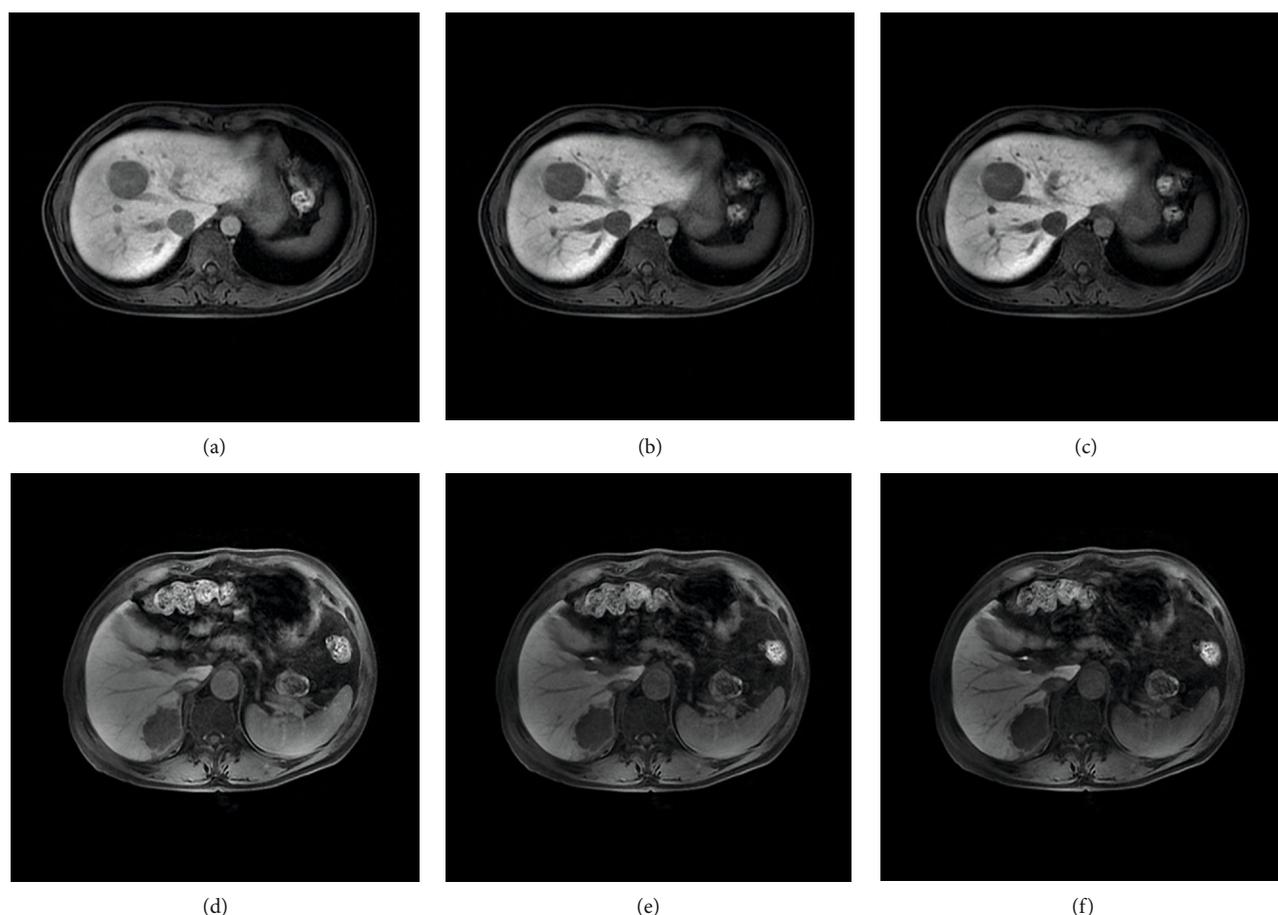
Axial MR imaging with Gd-EOB-DTPA on HBP in a HCC MVI-negative patient ((a) HBP 5 min, (b) HBP 10 min, and (c) HBP 15 min), and a MVI-positive patient ((d) HBP 5 min, (e) HBP 10 min, and (f) HBP 15 min). The imaging of MVI negative shows a smooth tumor margin, while MVI-positive shows a nonsmooth tumor margin. However, other tumor features between MVI positive and negative are difficult to identify by visual inspection.
